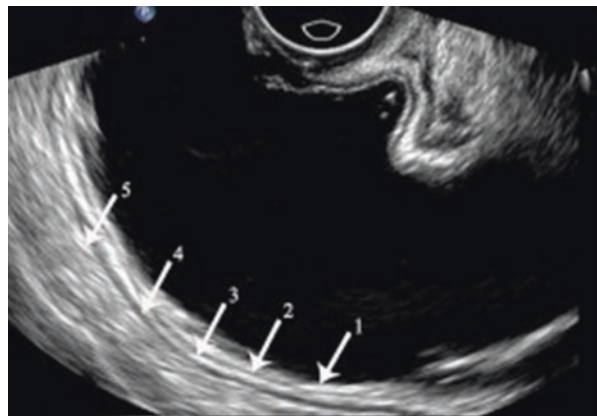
Layers of the gastrointestinal wall identified by endoscopic ultrasound (linear array echoendoscope)
